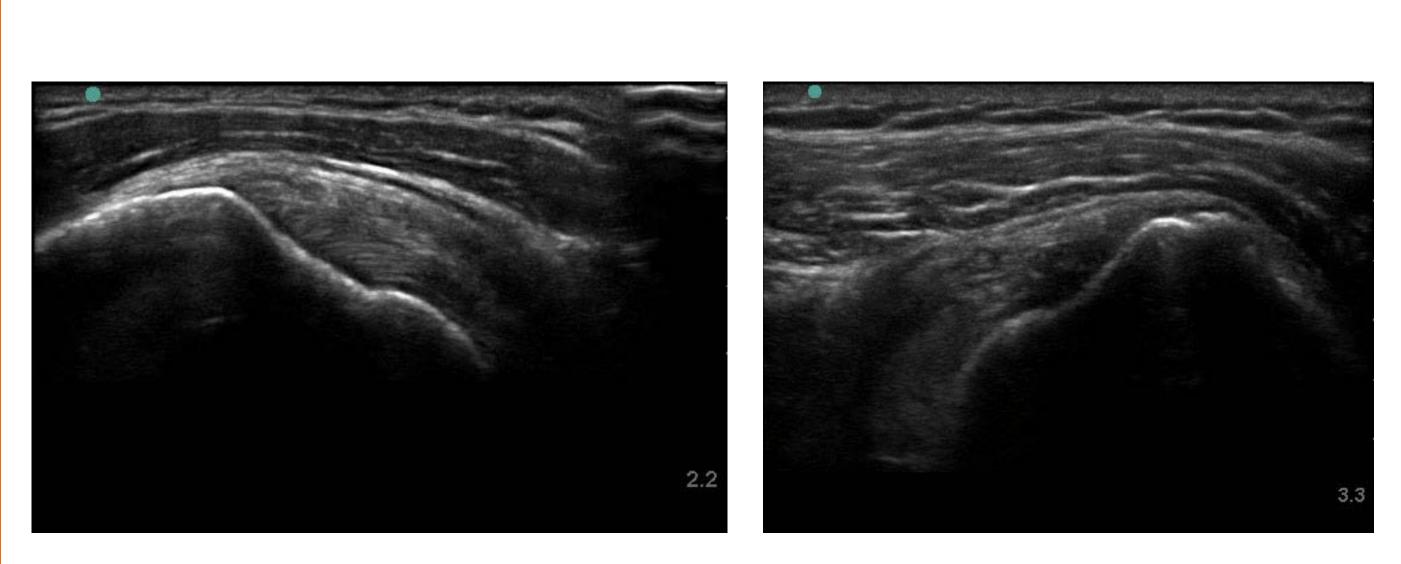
Ultrasound Images of rotator cuffs.
